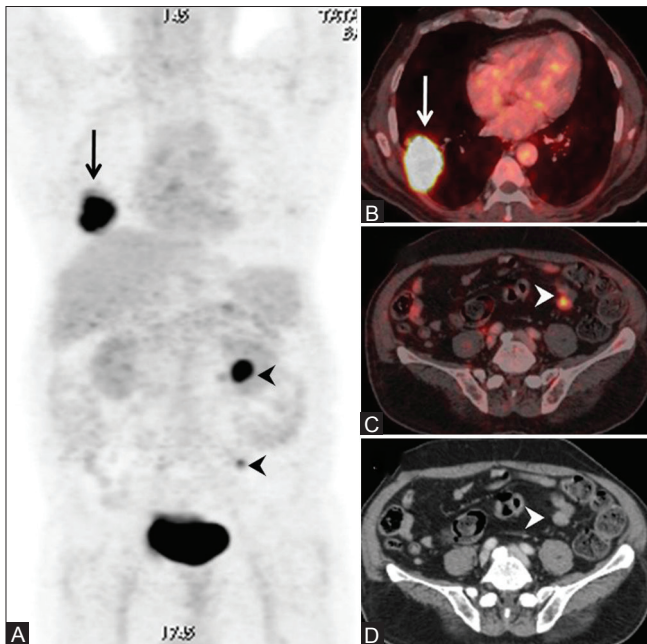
(A-D): Incremental value of FDG PET/CT in baseline staging. MIP image of FDG PET scan shows intense tracer concentration in the right hemithorax (arrow, A) corresponding to a right lung mass (arrow, B). Also seen are two FDG-avid foci in the abdomen (arrowheads, A) which correspond to peritoneal metastatic deposits (arrowhead, C). Note that the peritoneal deposit is almost indistinguishable from adjacent bowel (arrowhead, D). Due to PET/CT findings, the intent of treatment changes from curative surgery of a resectable mass to palliative chemotherapy
